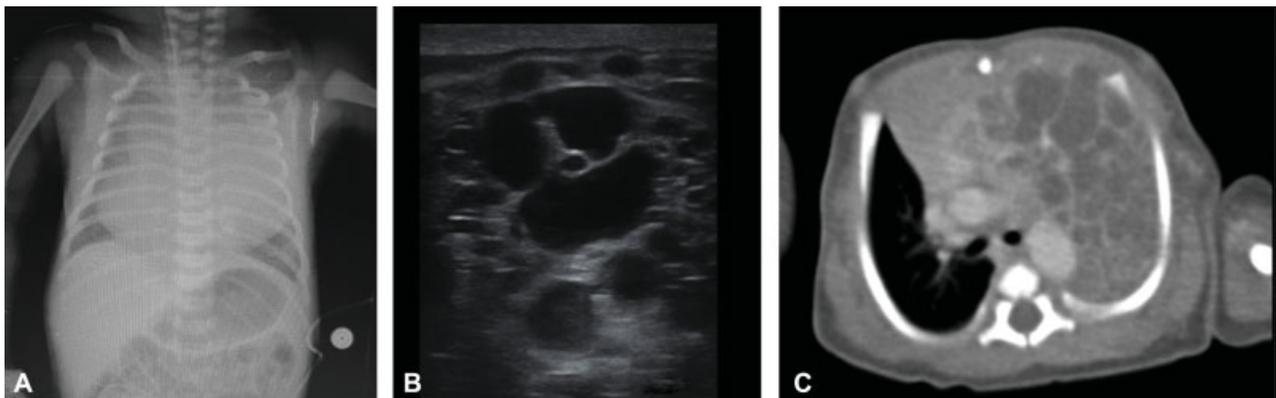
(A) CXR at birth: unclear diffuse opacity of the left hemithorax with apparent mediastinal and tracheal shift. (B) LUS-DOL 1: cysts of various dimensions (> 5 mm) in the context of left upper lobe. (C) CT-DOL 2: multisized cysts (> 5 mm) in the left upper lobe with transmediastinal herniation in the right hemithorax. CT, computed tomography; CXR, chest X-ray; DOL, day of life; LUS, lung ultrasound.
